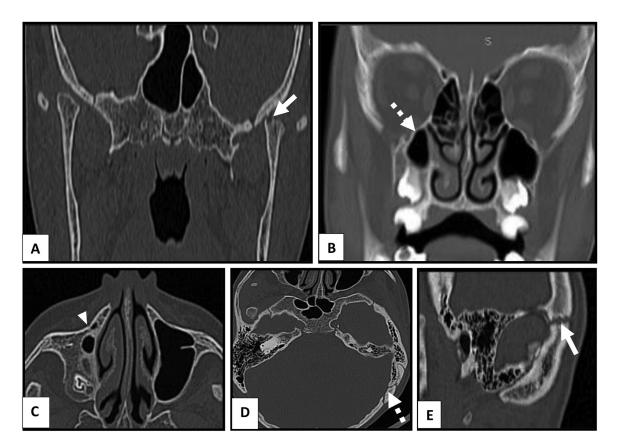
(A) Frontal section wide window CT scan through the mandibular branches and condylar heads revealing bicondylar shape anomaly with flattening of the articular surfaces and the presence of osteophytes, more pronounced on the left side (white arrow). (B) Frontal section wide window CT scan through the molar region revealing maxillary right sinus hypoplasia (dashed white arrow). (C) Axial section wide window CT scan of the maxillary sinuses revealing depression of the anterior surface of the right maxillary bone (arrowhead). (D) Axial section wide window CT scan revealing window CT scan revealing wormian bones (dashed white arrow). (E) Parasagittal section wide window CT scan revealing open lambdoid cranial suture (white arrow).
